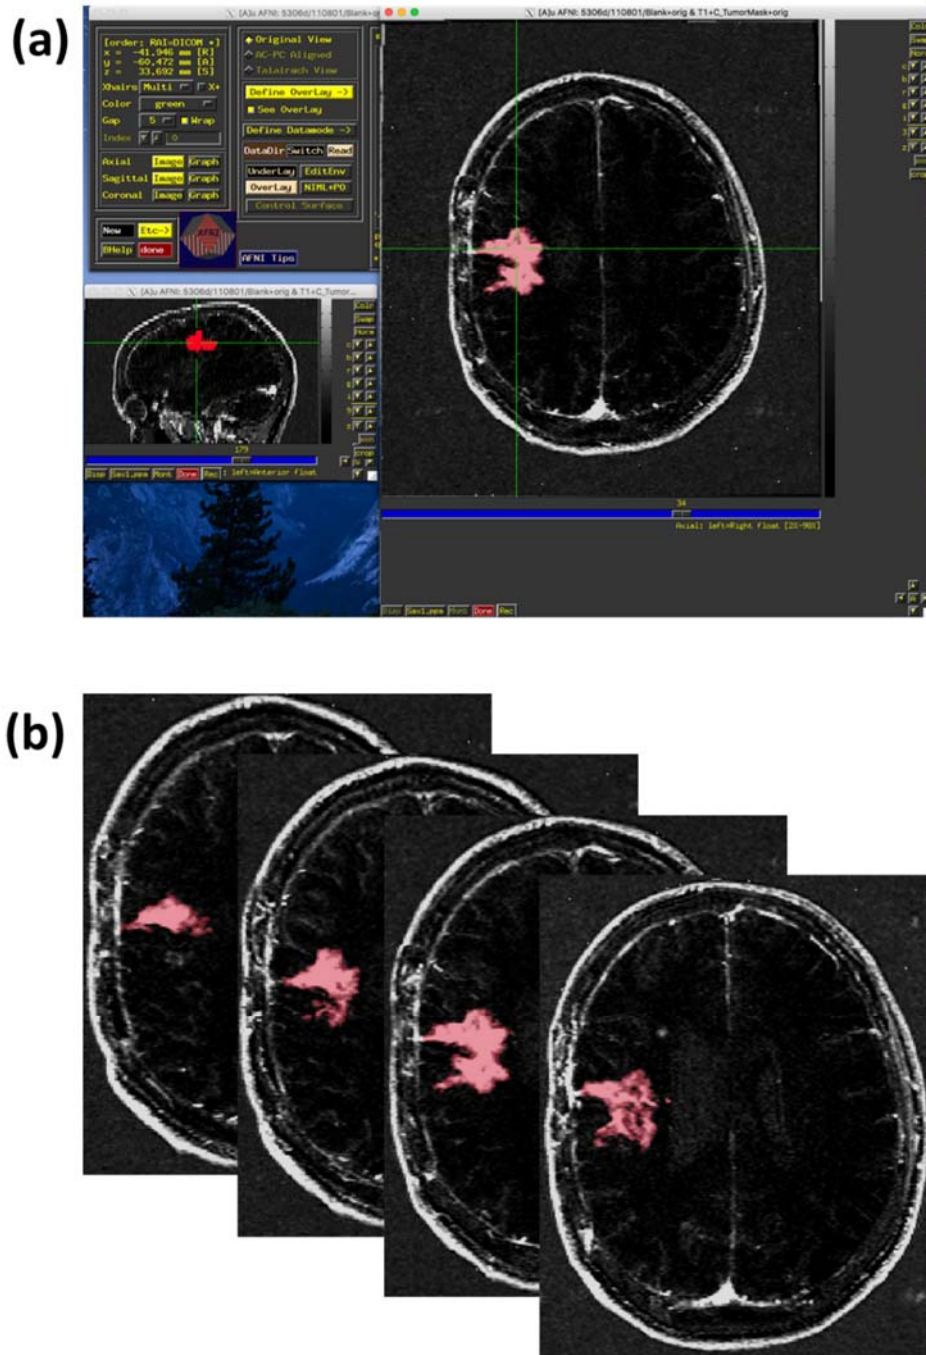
Operation of AFNI software. (a) Software interface. Basic information of MRI scan slices was shown at the upper left corner with available program functions. Tools to visualize scan slices and to draw ROIs were shown at the upper right corner. ROI was drawn on the tumor and highlighted in red. Selected tumor location (cross points of green lines) was displayed in 2 trajectories (x-y and y-z planes). (b) MRI scan slices of a GBM patient with ROIs drawn. ROIs were stacked and integrated into tumor volume.
